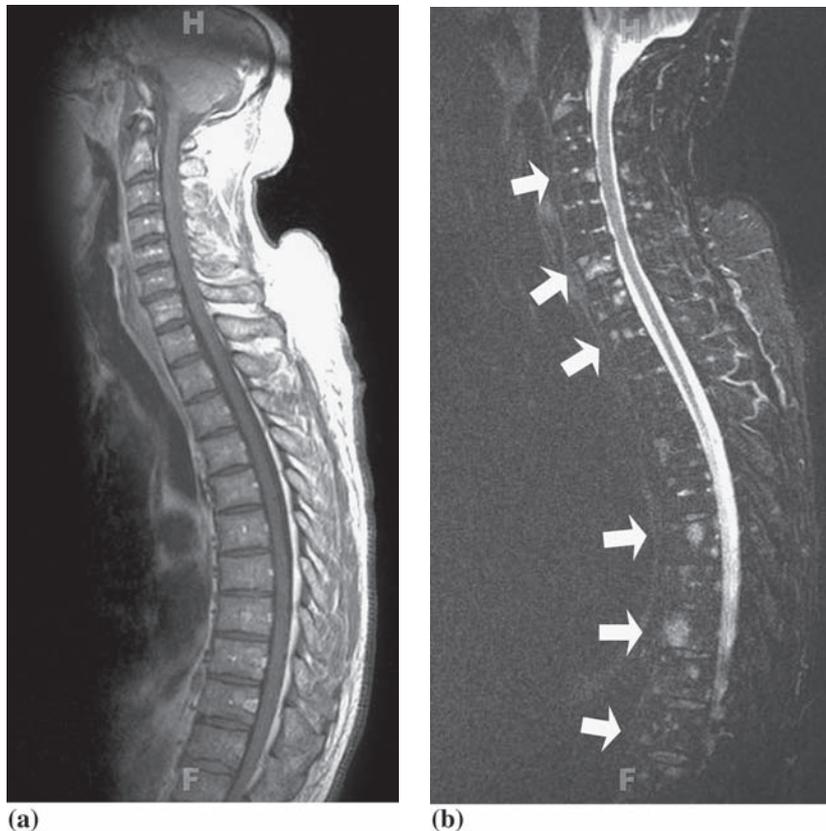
Diffuse prostate cancer metastasis. (a) Contrast-enhanced sagittal T1-weighted MR image does not reveal a definite enhancing lesion. (b) Sagittal STIR sequence shows multi-level bright tumor deposits (arrows) on the background of suppressed fatty marrow signal
